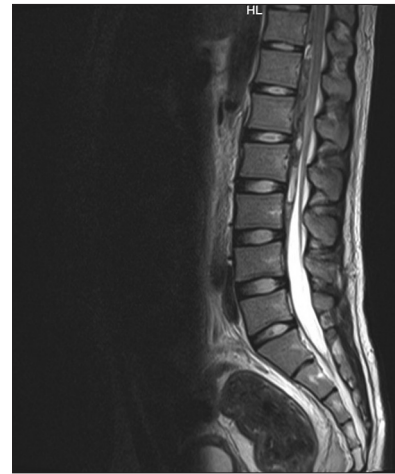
Magnetic resonance imaging lumbar spine sagittal cuts showing epidural haematoma
